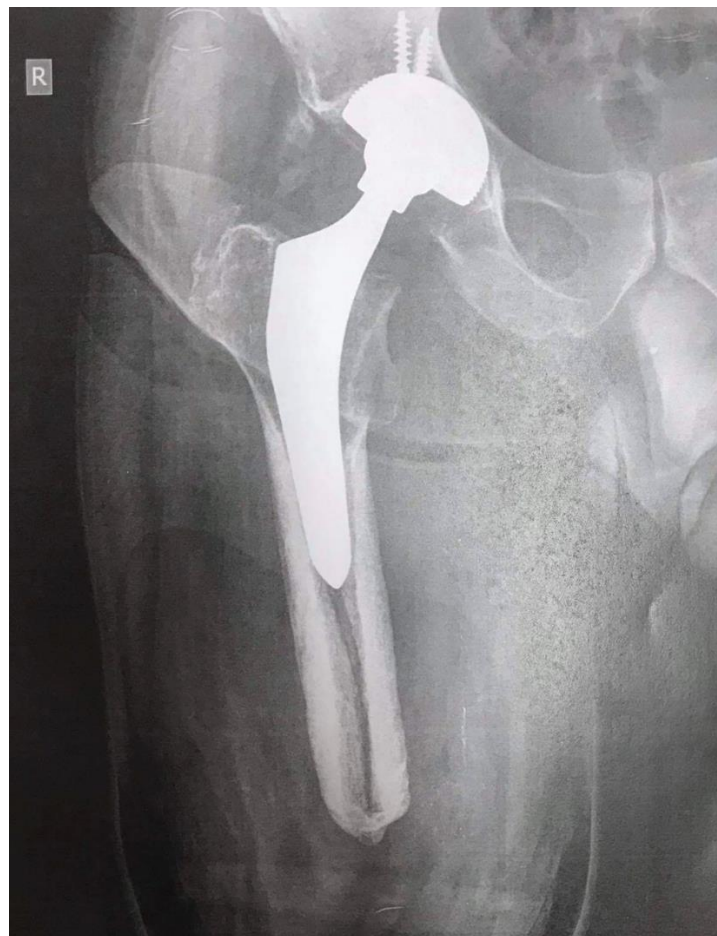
Postoperative radiograph at 6 months. No osteolysis and a well incorporated prosthesis was noted
